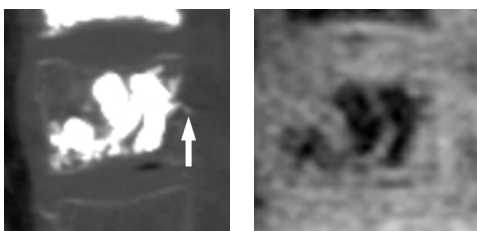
72-year-old female with compression fractures at T9. Coronal reformatted CT (left) shows treated vertebra with an intravenous leakage (arrow). Intravenous leakage is not visualized on uTE (right).
